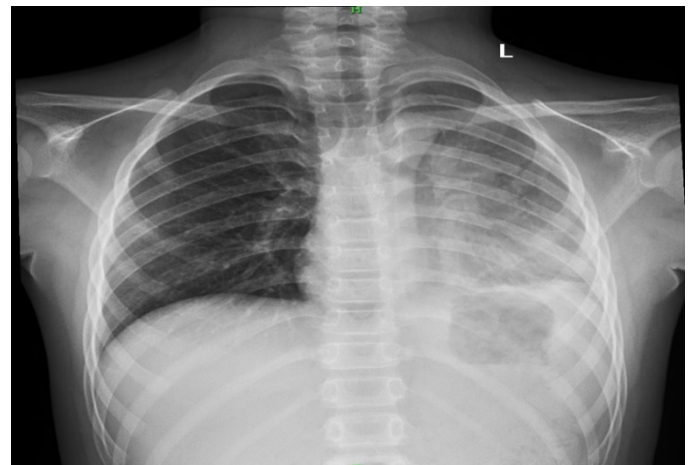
Figure a: Chest Xray PA view – Collapsed Left Lung.
